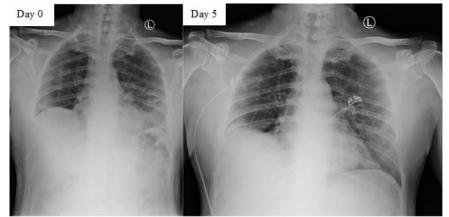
Serial chest x-ray showed improvements on day 5 after receiving two times aaPRP treatments
